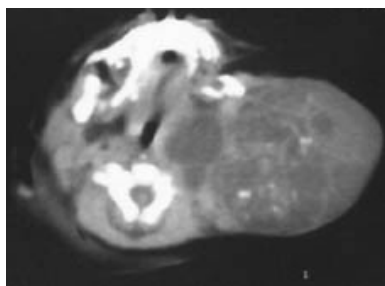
Neck CT demonstrating a solid and cystic mass in the left anterior neck region that contains multiple tissue elements including fat, soft tissue, and calcification.
